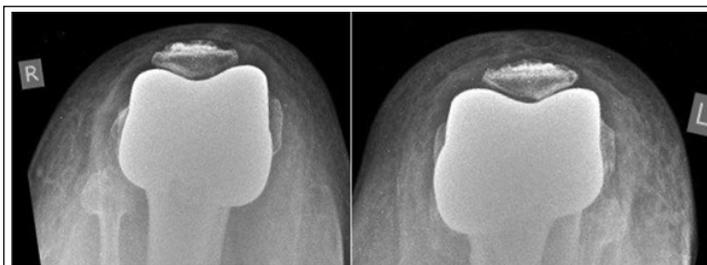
Post-operative skyline view X-rays showing the positioning of the patella in the trochlear groove of the prosthesis.
